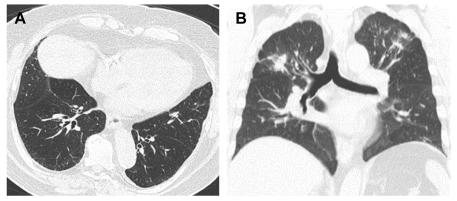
Axial and coronal HRCT images of coal worker's pneumoconiosis, with upper lobe predominant peribronchovascular nodules and conglomerate masses.
